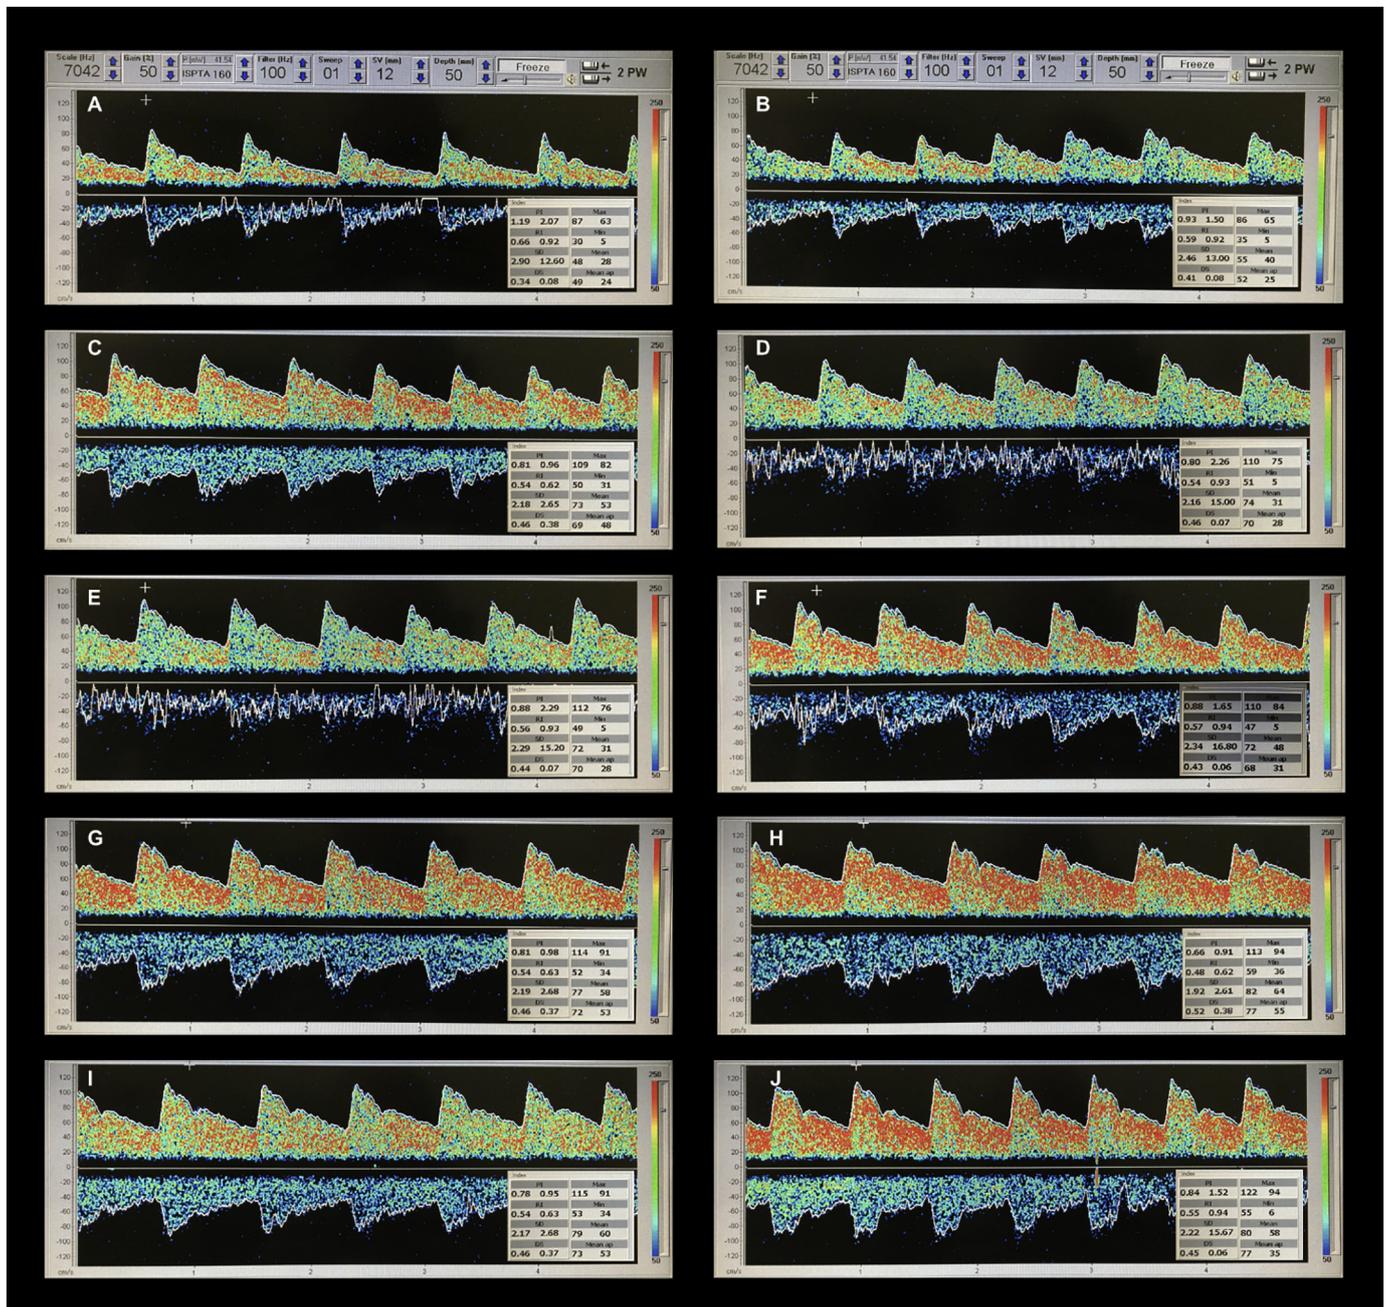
TCD raw tracings and TCD velocimetric values. Resting state: (A) Right MCA, (B) Left MCA. Right Leg Passive Movement: (C) Right MCA, (D) Left MCA. Right Leg Motor Imagery: (E) Right MCA, (F) Left MCA. Alternating Leg Passive Movement: (G) Right MCA, (H) Left MCA. Alternating Leg Motor Imagery: (I) Right MCA, (J) Left MCA. Abbreviation. TCD: Transcranial Doppler. MCA: Middle Cerebral Artery.
